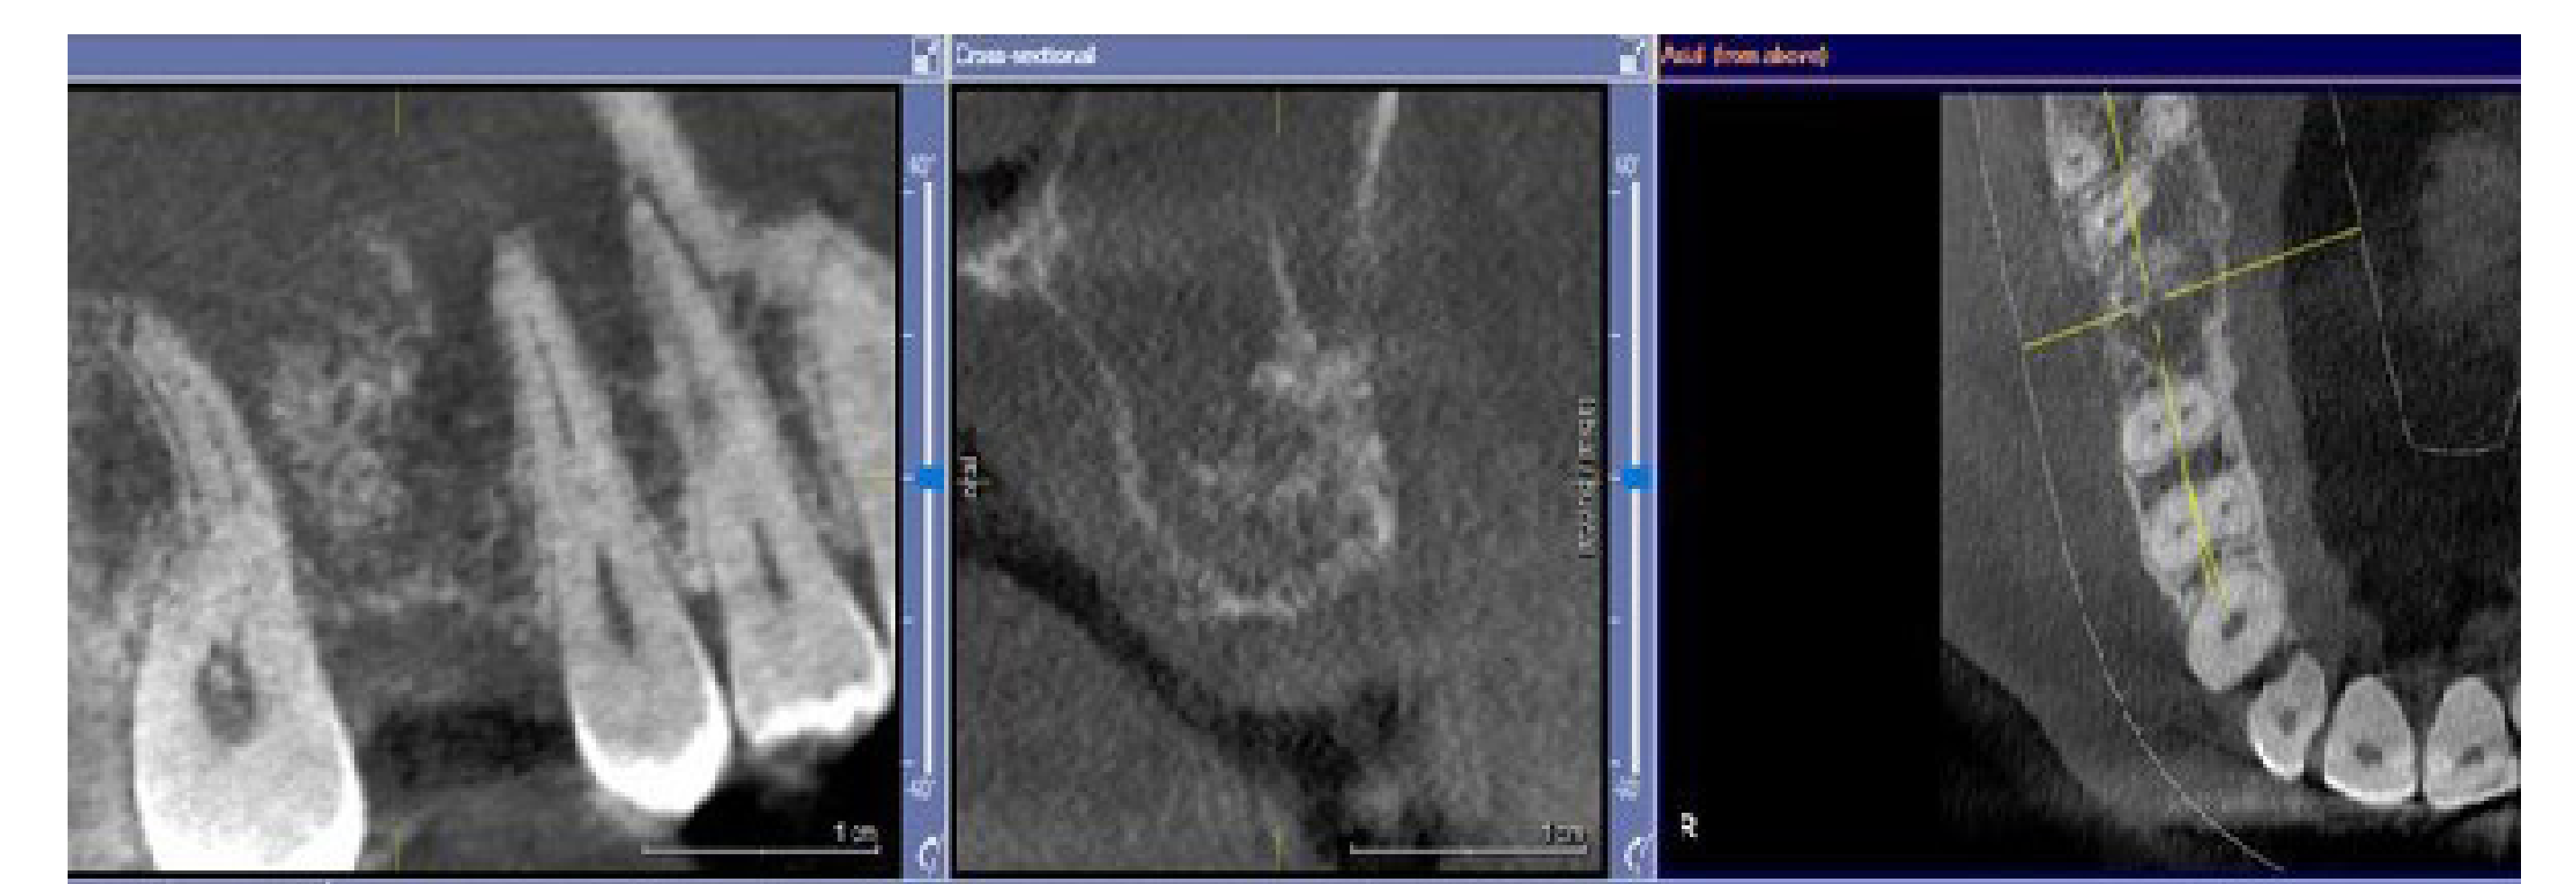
CBCT images, start of new bone formation after 2 months.
